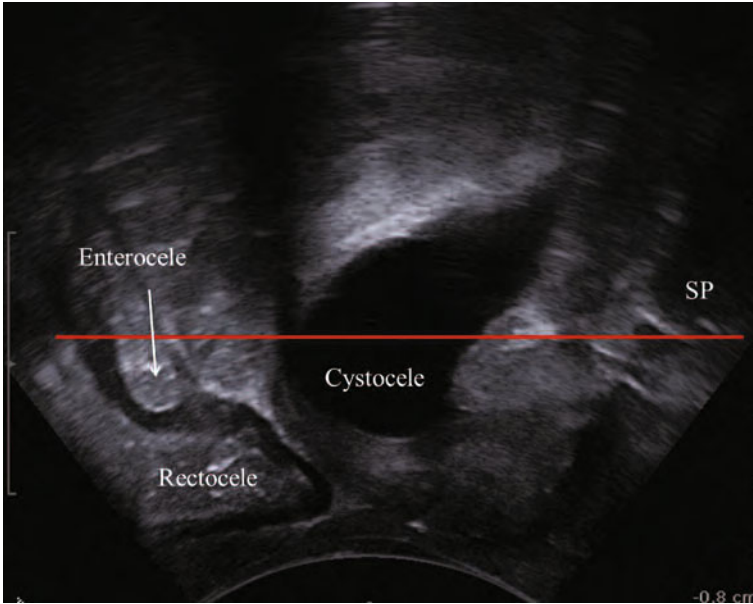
Two-dimensional transperineal ultrasonography. Midsagittal view of multicompartmental prolapse, appearing as displacement of the pelvic organs below the referral line (*red line*, horizontal to the inferior margin of the symphysis pubis *SP*)
